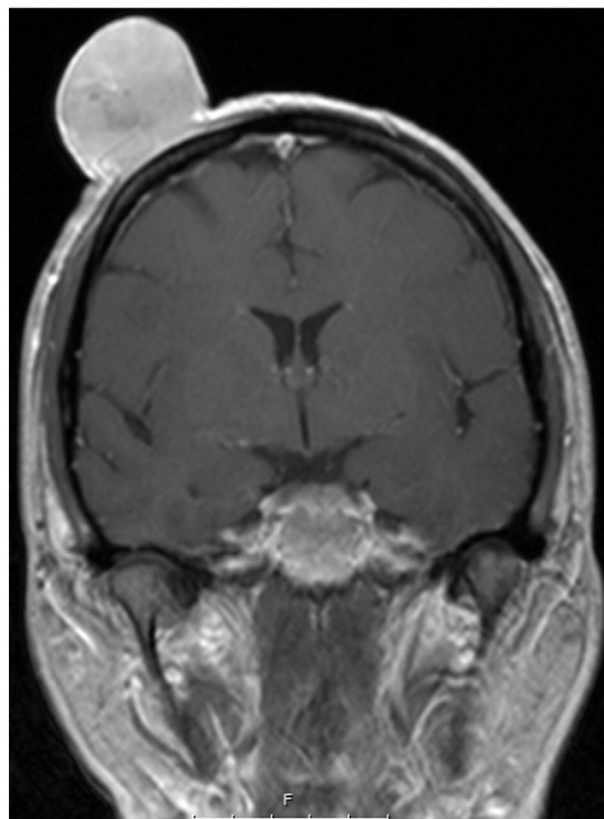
Sagittal T1 weighted MRI post gadolinium of the head showing a 4.6 × 4.2 × 4.3 cm solid enhancing soft tissue mass arising from the right frontoparietal scalp with mild thickening of the underlying subgaleal layer. There is no evidence of bony cortex invasion or marrow signal abnormality.
